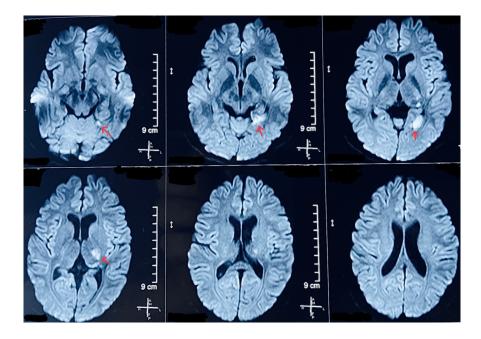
Diffusion-weighted magnetic resonance imaging of brain showing restricted diffusion involving posterior limb of internal capsule and occipital lobe.
